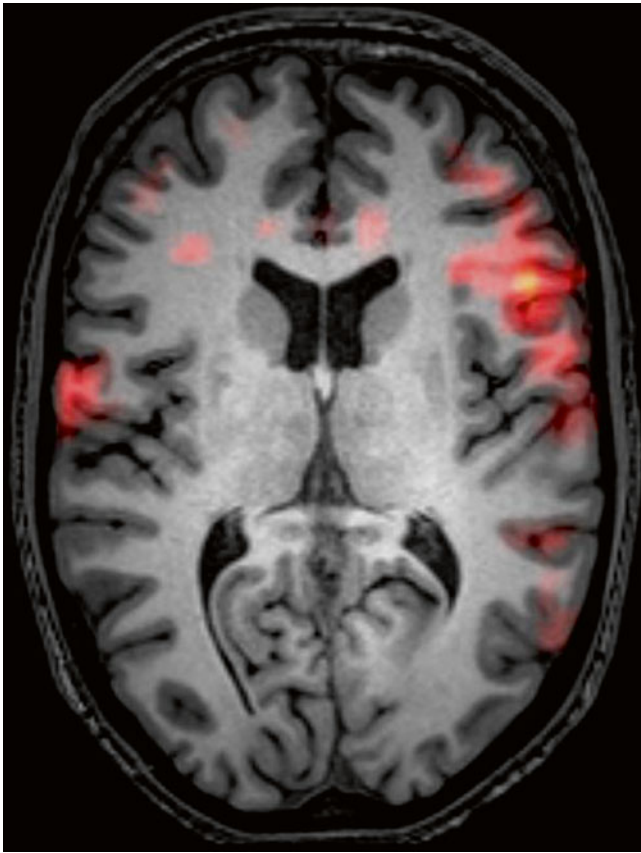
Functional MRI. *Red* areas indicate activation during a simple word generation task. Activation is seen predominantly in the left hemisphere in the frontal language region; typical language lateralization
